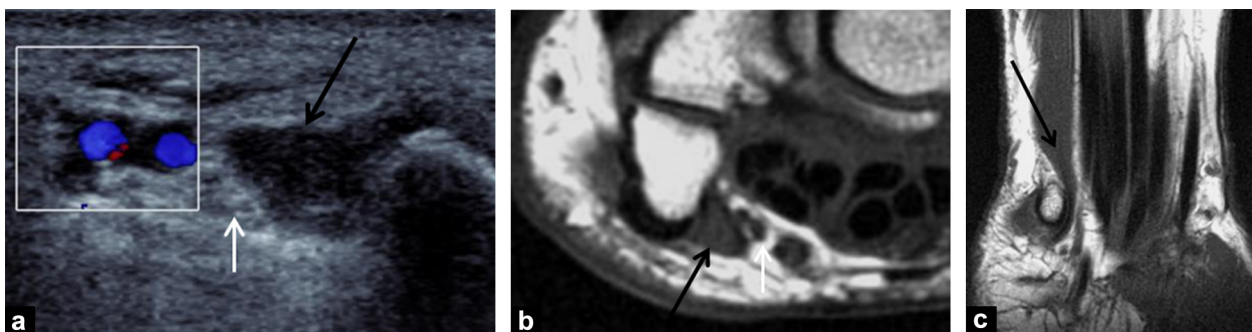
Guyon's tunnel syndrome due to a compressive accessory 5th finger long flexor muscle. a: ultrasound shows muscle mass (black arrow) in Guyon's tunnel adjacent to the ulnar nerve (white arrow); b: T1-weighted images in the (b) axial and (c) coronal planes show the accessory muscle (black arrow) in the Guyon tunnel, adjacent to the ulnar nerve (white arrow).
